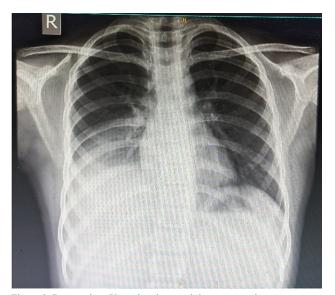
Repeat chest Xray showing resolving pneumonia
